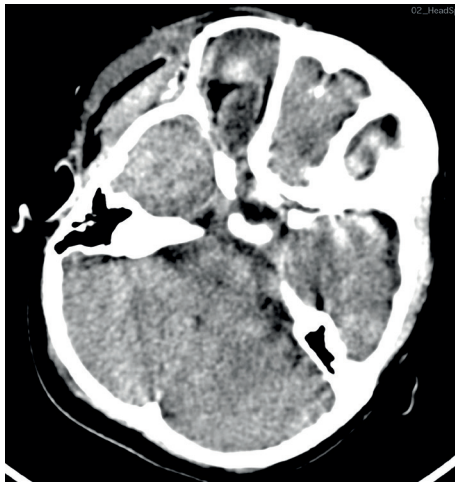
Post-operation CT scan of Brain shows no hematoma
